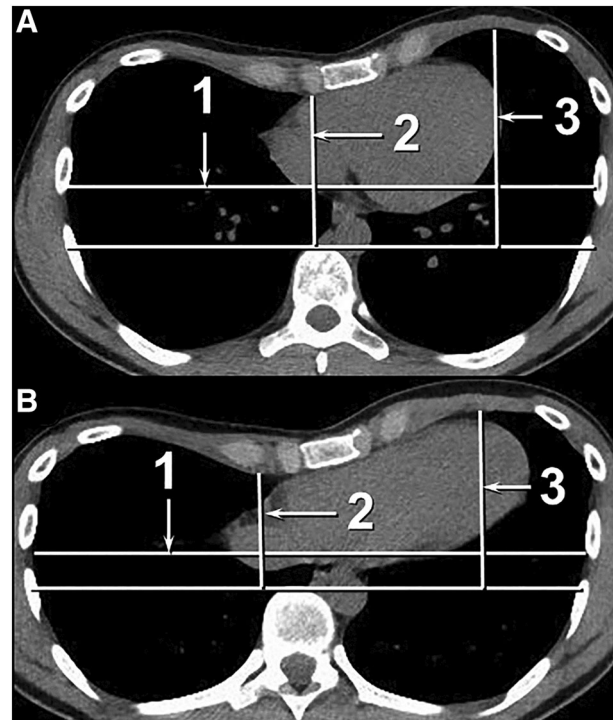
Unenhanced inspiratory (a) and expiratory (b) thoracic CT obtained for pectus excavatum shows measurement of the maximal transverse thoracic diameter (1), and the minimum antero-posterior thoracic dimension (2). The pectus, or Haller Index is given by (1)/(2). The correction index is calculated as follows: (3)–(2)/(3) × 100%. On the inspiratory study, the maximum transverse thoracic diameter (1) was 258.6 mm and the minimum antero-posterior thoracic dimension (2) was 76.1, yielding a pectus (Haller) index of 3.4. The value for (3) was 108.6 mm, yielding a correction index of 30%. On inspiratory imaging, the maximum transverse thoracic diameter (1) was 253.2 mm and the minimum antero-posterior thoracic dimension (2) was 52 mm, yielding a pectus (Haller) index of 4.9. The value for (3) was, 79.9 mm, yielding a correction index of 35%
